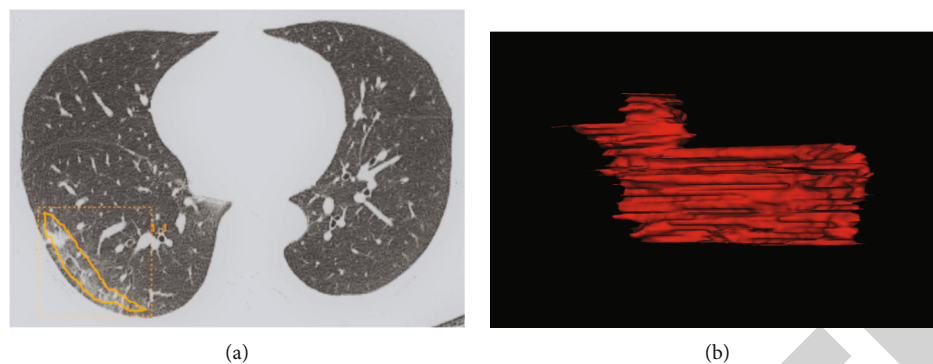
A case of confirmed COVID-19 of the resorption stage. A 63-year-old male presented with a 15-day history of fever and cough. (a). CT imaging revealed pure GGO with reticular distributed in the right lower lobe. The area of the lesions was delineated on the axial. (b) The reconstructed images.
